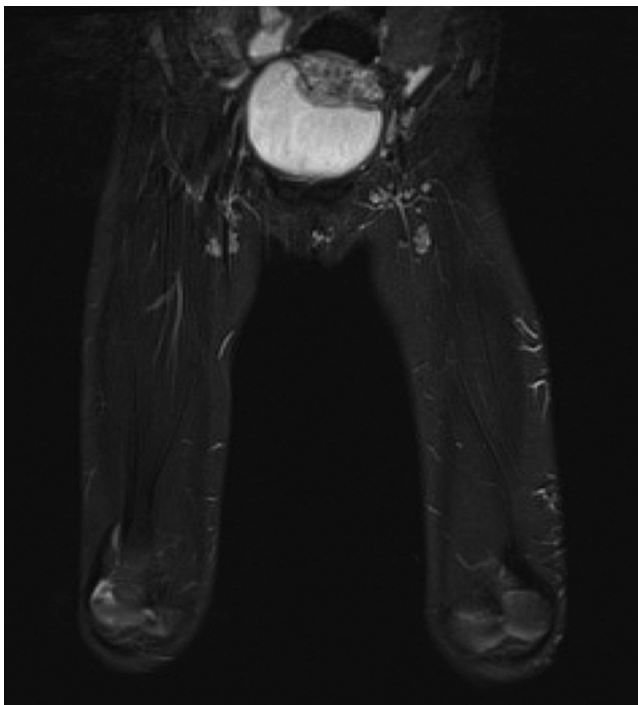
A T2-weighted inversion and T1-weighted recovery magnetic resonance image revealing a large mass in the vesical dome.
